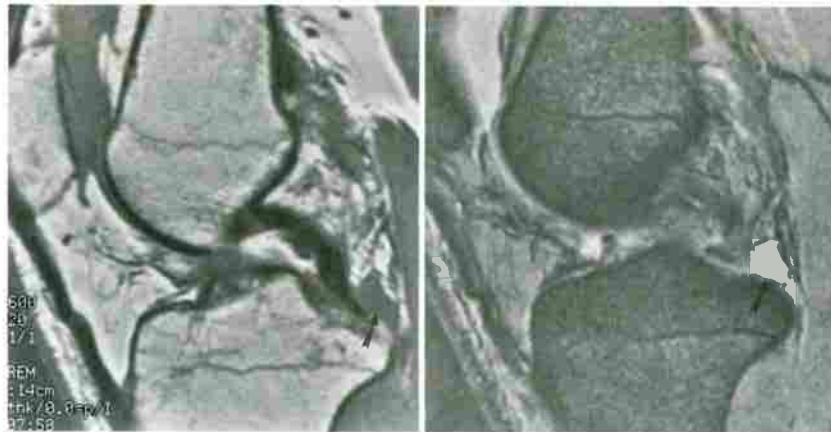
Sagittal (A) T1-weighted (TR/TE, 600/20) and corresponding (B) gradient-echo (TR/TE, 483/20; angle, 30 degrees) images. Ganglion cyst arising from the tibial insertion of the posterior cruciate ligament (arrow) appears as a low-signal-intensity, well-circumscribed mass on the T1-weighted image and shows homogeneous increased signal intensity on the gradient-echo image.
